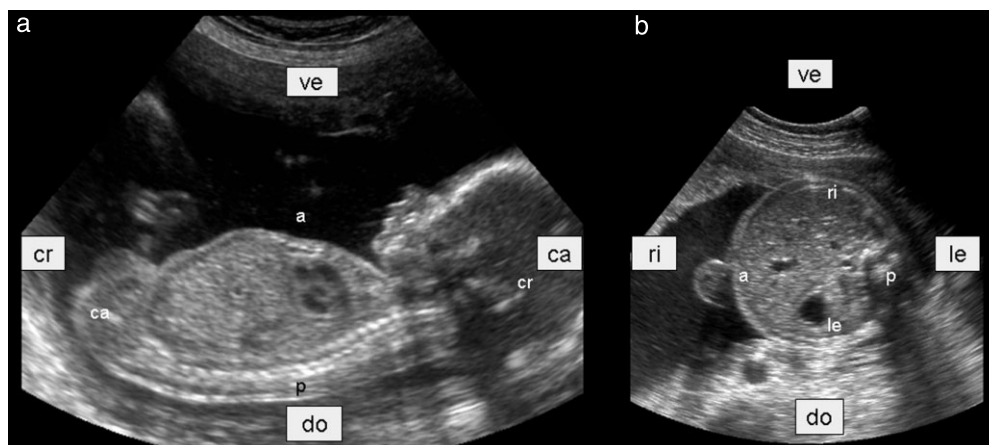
Transabdominal ultrasound images of a fetus with vertex presentation: sagittal (a) and transverse (b) sections. Labels in boxes refer to the anatomy of the mother, while labels without boxes refer to that of the fetus. a, anterior; ca, caudal; cr, cranial; do, dorsal; le, left; p, posterior; ri, right; ve, ventral.
